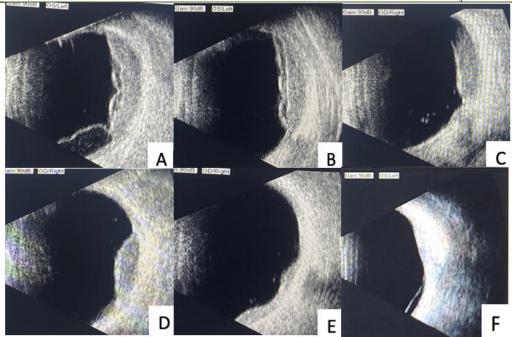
Ultrasound images of choroidal masses in both eyes; Isoechoic polylobed lesions with a bumpy surface, accompanied by exudative retinal detachment (A-B); Typical umbilicate lesion of choroidal metastasis (C); A raised isoechoic lesion (D); A domed choroidal mass without central excavation, which distinguishes it from choroidal melanoma (E); An iso-echoic lesion wider than tall (F); (AVISO echography, Ophtalmology Department, Hassan II University Hospital of Fez)
